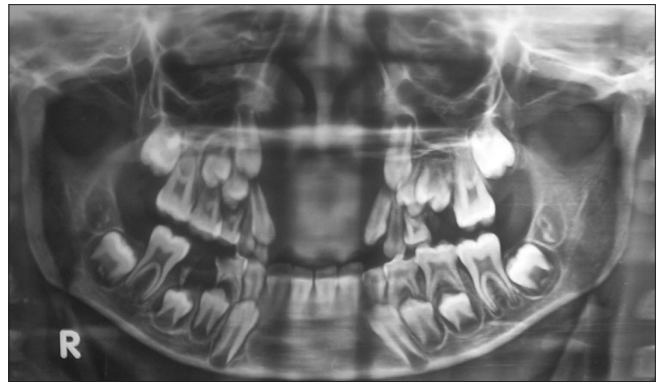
Orthopantomograph revealed a purely osteolytic lesion in the anterior maxilla
